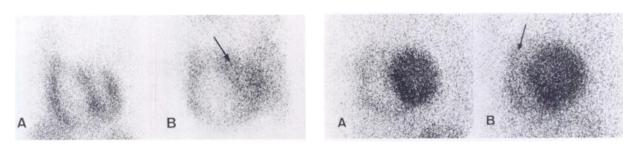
Myocardial scintigrams of patient with primary pulmonary hypertension. (A) LAO 45° view, showing dilated right ventricle and small left ventricle, with straight-looking septum. (B) LAO 60° view made 7 mo after (A), showing markedly dilated right ventricle and contracted left ventricle (arrow).
